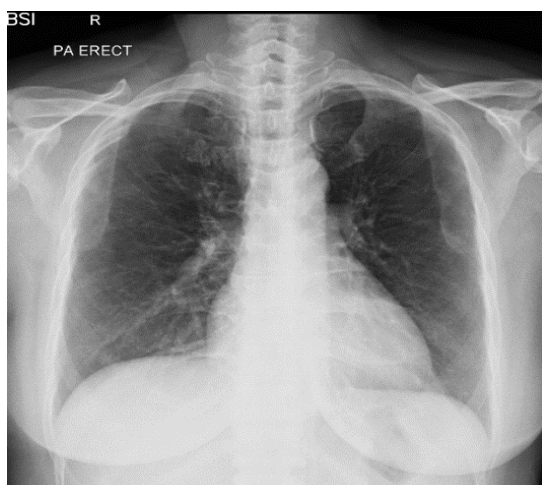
Chest X-Ray Examination Result
